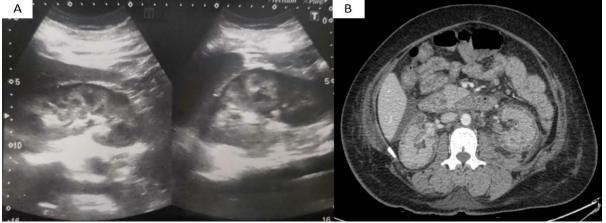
Radiological findings in acute cortical necrosis. A- Ultrasound both kidneys showing hypoechoic peripheral rim. However, there is preserved cortico-medullary distinction. B- CT scan: Post contrast: Axial view: There is a non-enhancing renal cortex (yellow arrow) and a normal enhancing renal medulla which is called reverse rim sign. A very thin rim of contrast enhancement (cortical rim sign) is also seen (blue arrow). These findings are present in bilateral symmetrical pattern.
